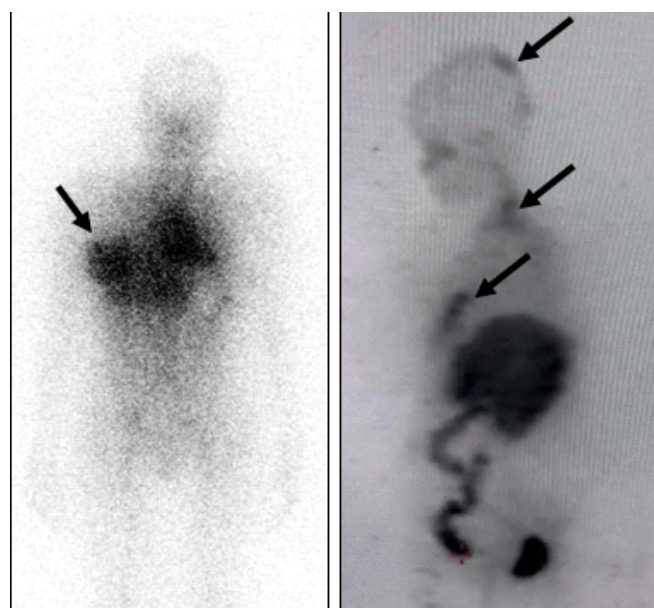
SPECT scans of two patients depicting the accumulation of [^{177}Lu]Lu-DOTA-Trastuzumab (shown with arrows) in cancerous lesions (Image courtesy: Dr. Venkatesh Rangarajan, TMH Parel and Dr. Nandini Pandit, JIPMER, Puducherry).
